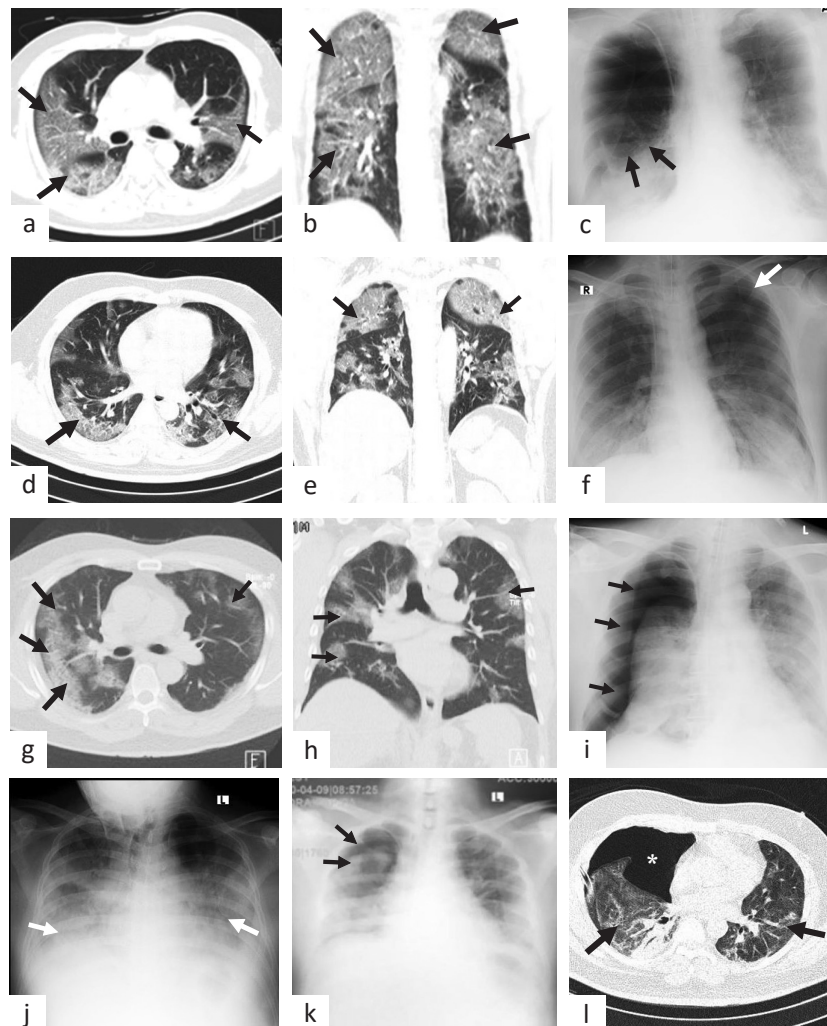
Chest CT scan and CXR of the COVID-19 cases. Case-1 (a, b, c), coronal (a) and axial (b) views of the chest CT scan on admission showing GGO and multifocal crazy paving pattern (arrow), CXR on day-14 (c) showing right lung hydropneumothorax and atelectasis (arrow); case-2 (d, e, f), chest CT scan on admission (d, e) showing GGO and multifocal crazy paving pattern (arrow), CXR on day-10 (f) showing left lung pneumothorax (arrow); case-3 (g, h, i), CT scan on admission (g, h) showing multifocal GGO (arrow), CXR on day-8 (i) showed right lung pneumothorax (arrow); case-4 (j, k, l), CXR on admission (j) showing opacities involving both lungs (arrow), CXR on day-20 (k) showing right lung pneumothorax (arrow), chest CT image on day-21 (l) showed right lung pneumothorax (asterisk) and GGO (arrow). COVID-19=coronavirus disease 2019; CT=computed tomography; CXR=chest X-ray; GGO=ground-glass opacity
